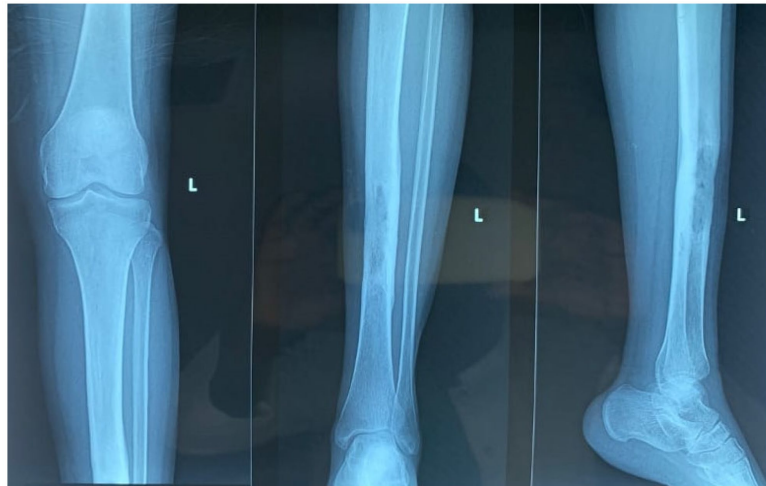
X-ray of the patient's left leg 6 months after the start of treatment.
